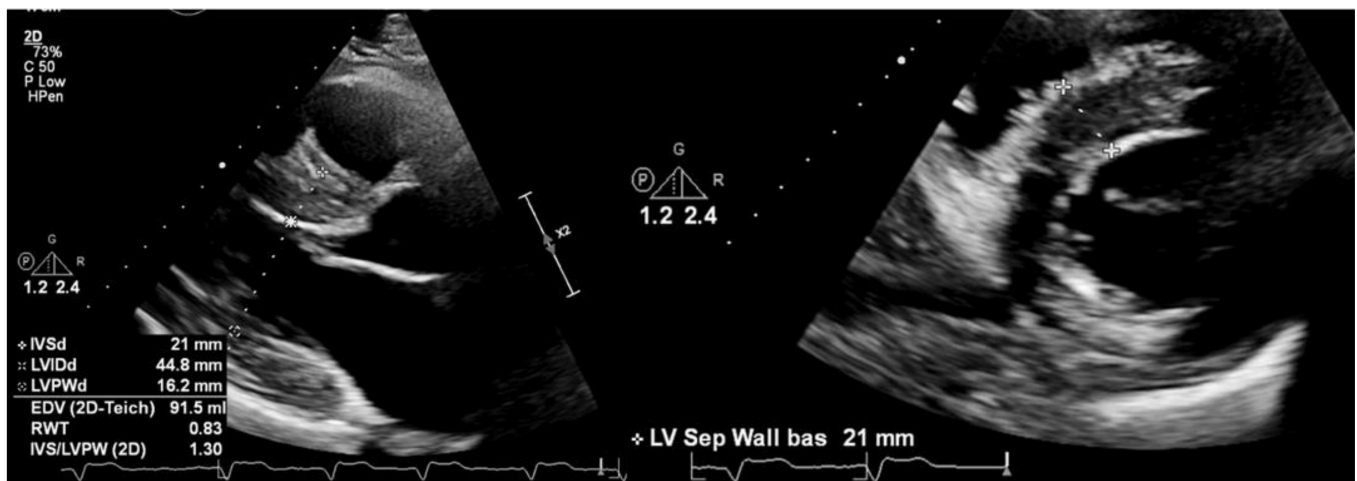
(Left) Parasternal long axis 2D TTE demonstrating linear measurements of IVS, LVID and LVPW demonstrating severe LVH; (Right) Parasternal short axis 2D TTE demonstrating severe LVH with MWT of 21 mm. Both images are taken from an adult male with advanced cardiomyopathy related to FD.
